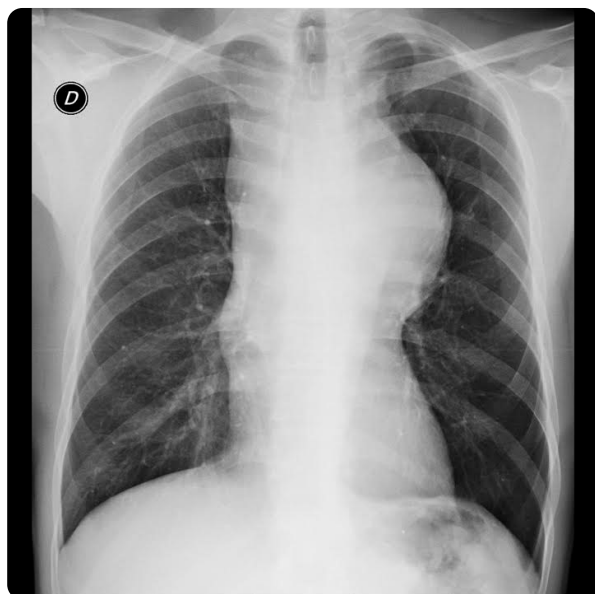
Chest X-ray. On the left, a posteroanterior view, in which the mediastinum is bilaterally widened with left predominance. On the right, the profile projection, showing a decrease in the retrosternal space, which may correspond in this topography to dilatation of the ascending aorta, with effacement of the aortopulmonary space.
